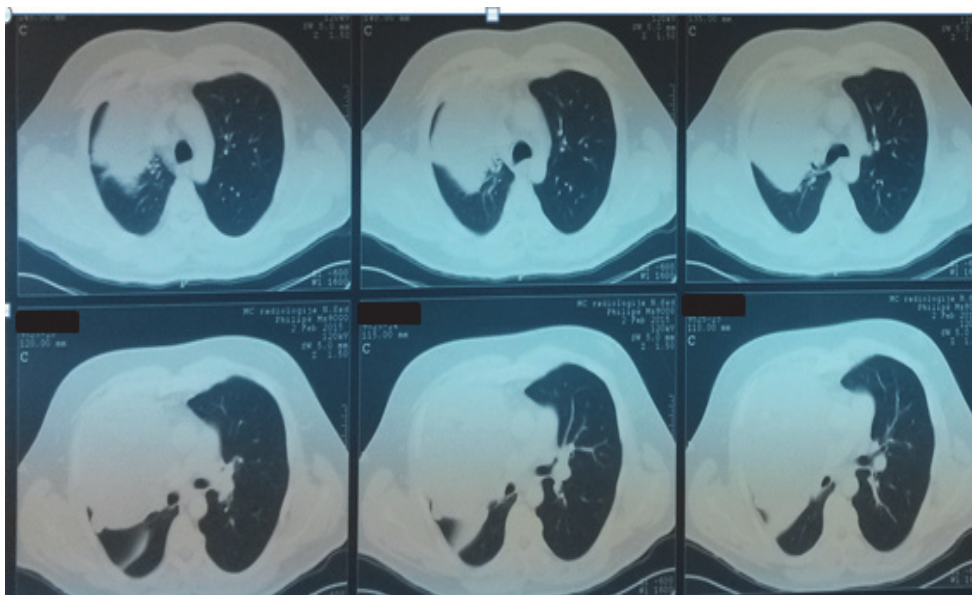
Chest computed tomography scan at the admission.
